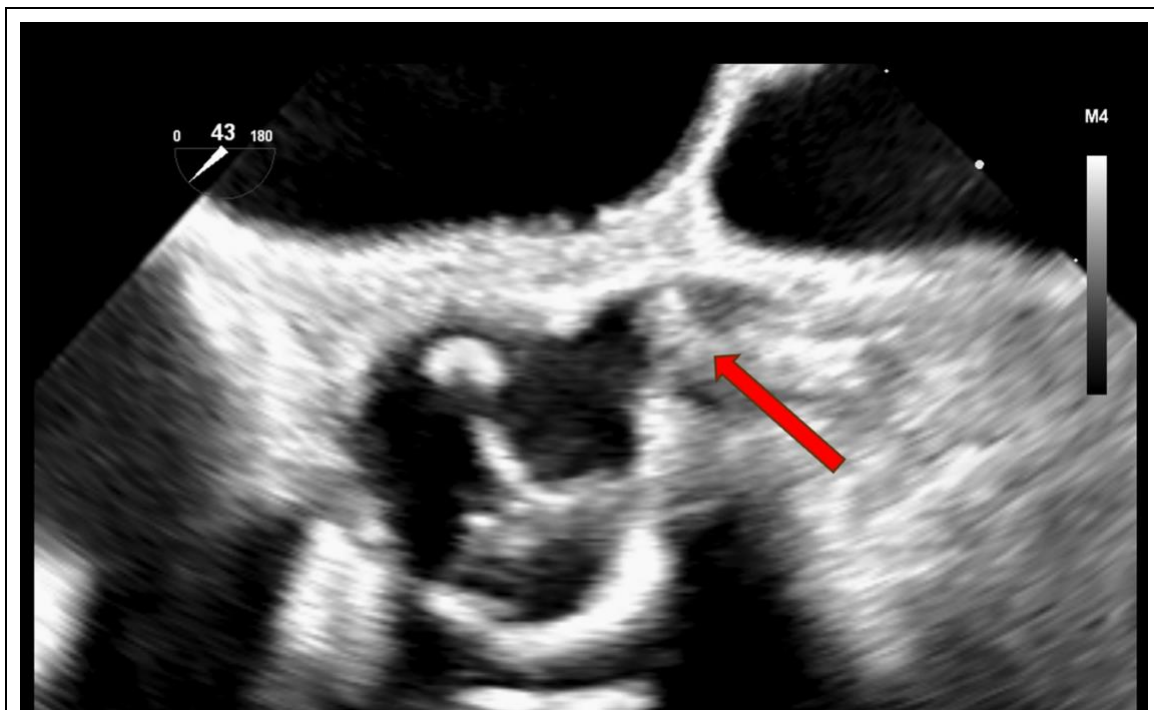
Direct visualization of left main coronary artery thrombus on transesophageal echocardiography.
